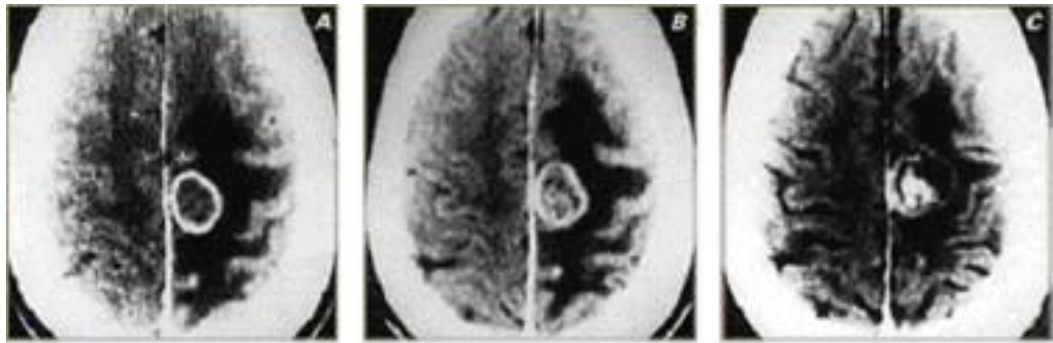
Transverse plane CT image of a metastatic brain tumor, before treatment (left), after 4 months (center) and 9 months (right) from a Gamma Knife radiosurgery. The tumor is smaller and the surrounding brain swelling is reduced.
